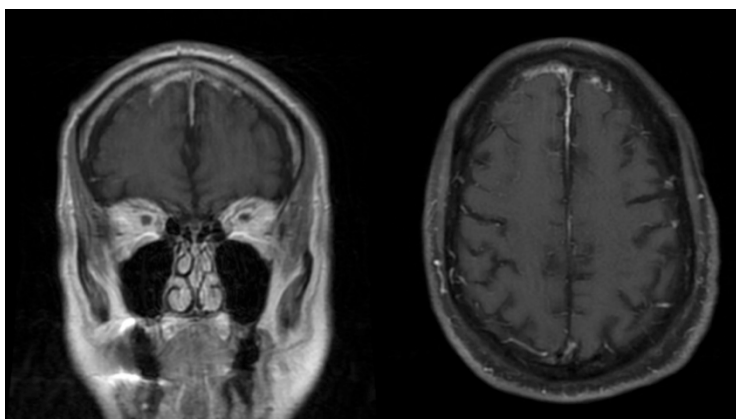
MRI brain with coronal and axial T1 demonstrating leptomeningeal enhancement from bacterial meningitis.
